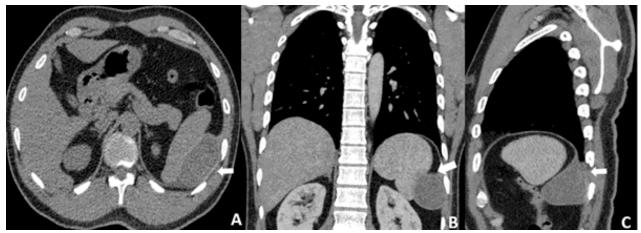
Contrast-enhanced CT of thorax and abdomen axial (A), coronal (B) and sagittal (C) images
